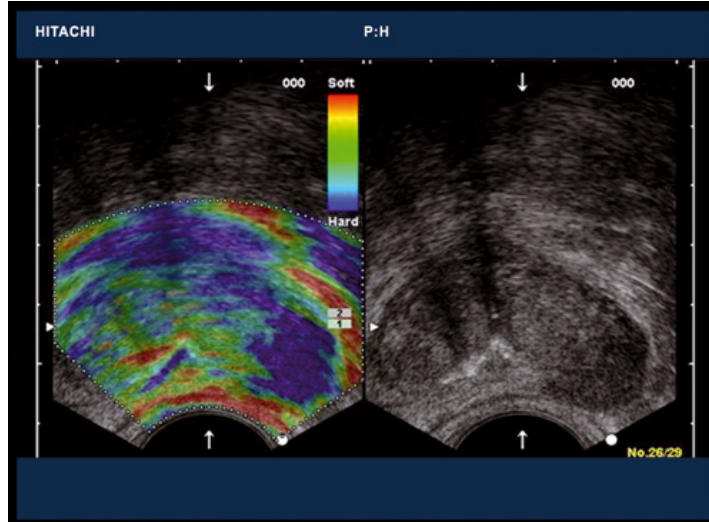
An example elastography result for the prostate using a rectal probe. Left: overlaid colormap represents recovered elasticity. Right: corresponding ultrasound image. Courtesy of Hitachi Medical Systems.
